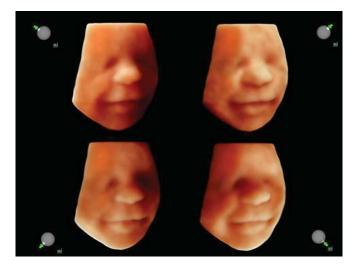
to F: Different display modes in 3D/4D ultrasound. (A) multiplanar view (fetal face), (B) tomographic view (fetal brain, sagittal planes), (C) surface view (face), (D) transparent view (spine), (E) glass body view with color Doppler (blood circulation), (F) glass body view with power Doppler (blood circulation)
